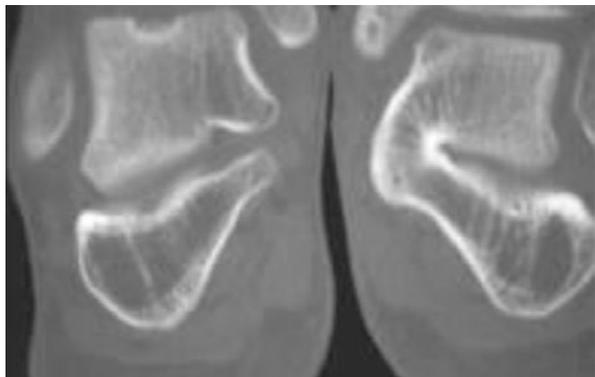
Tarsal coalition in coronal radiograph: note loss of middle facet of subtalar joint in right image
